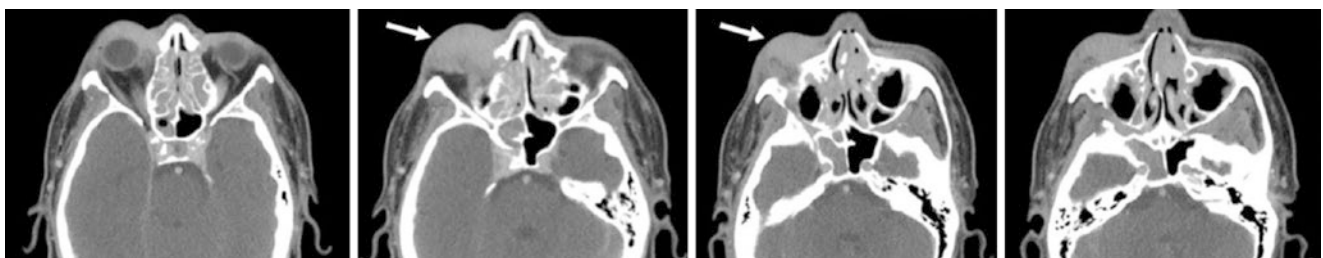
CT scans showing ill-defined, infiltrative soft tissue density involving the preseptal lower lid and premaxillary soft tissue (white arrow). Diffuse sinonasal inflammation with polypoidal soft tissue densities is also present
